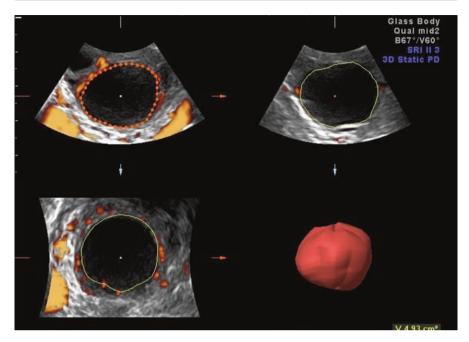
3D ultrasound acquired volume of the follicle with VOCAL calculated volume of the follicle
